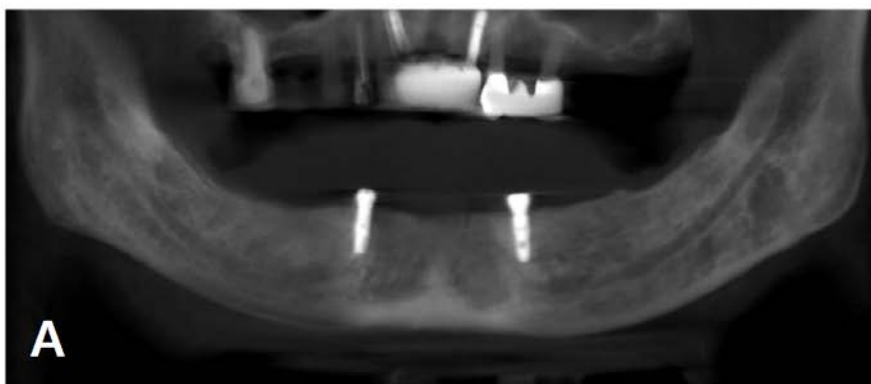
CBCT image after #33 implant installation. (A) Panoramic view, (B) Paraxial view.
